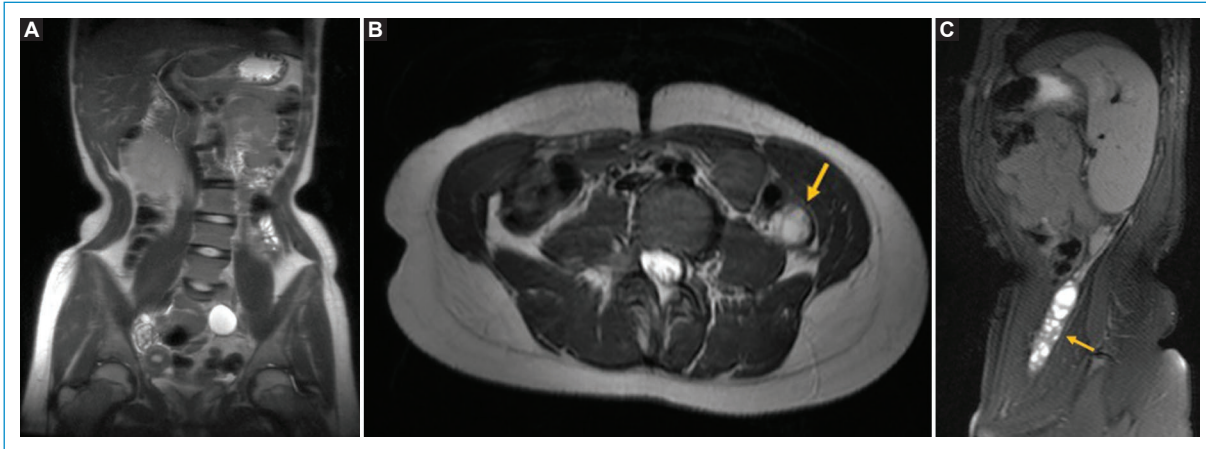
Ectopic ovary. Coronal (A), axial (B) T2-weighted and sagittal (C) fat-suppressed T2-weighted images showing an elongated, well-circumscribed structure on the left flank (yellow arrow). The right ovary is identified on the pelvis (black arrow) as well as the pelvic multicystic dysplastic kidney (*). An unicornuate uterus is also depicted (yellow arrow-head).
